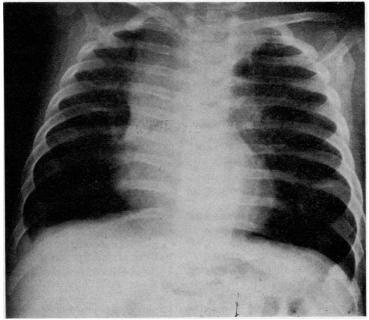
Chest radiograph taken at the age of 6 months showing hyperinflation with areas of increased transradiancy, especially at the bases.
